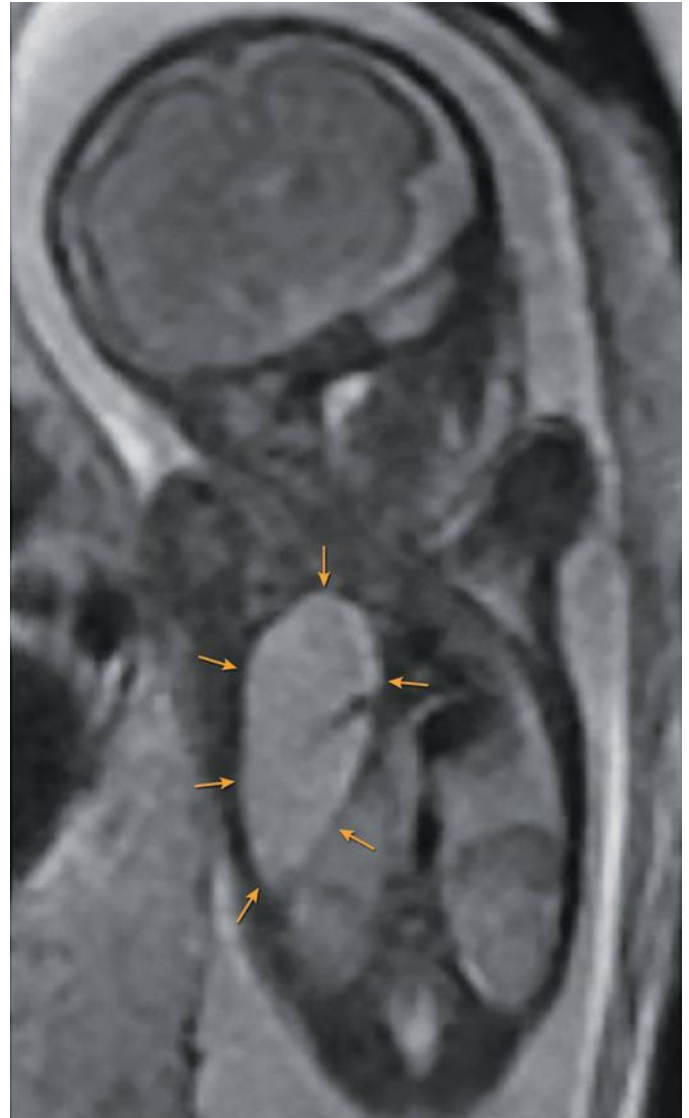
Congenital lobar overinflation at 26 weeks' gestation. Coronal T2-weighted imaging demonstrates expanded, hyperintense right mid-upper lobe (arrows) compared with normal-appearing right lower lobe and left lung. Postnatal computed tomography confirmed congenital lobar emphysema likely due to right middle lobe bronchial atresia.
